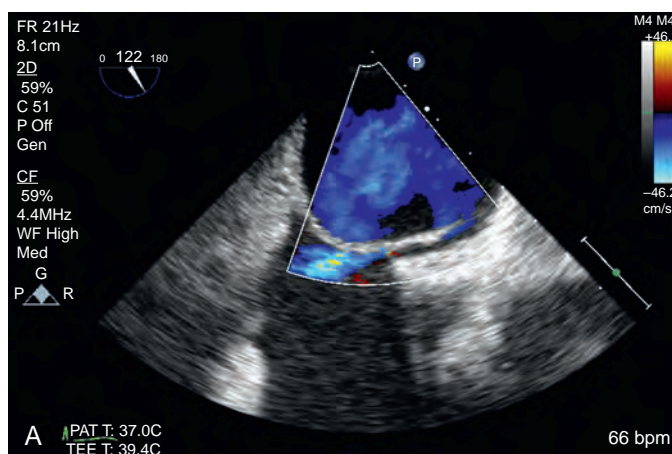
(A) Bicaaval view demonstrating flow from left to right with color-flow Doppler echocardiography. (B) Bicaaval view demonstrating a positive saline agitated study with right-to-left flow between both atria.
